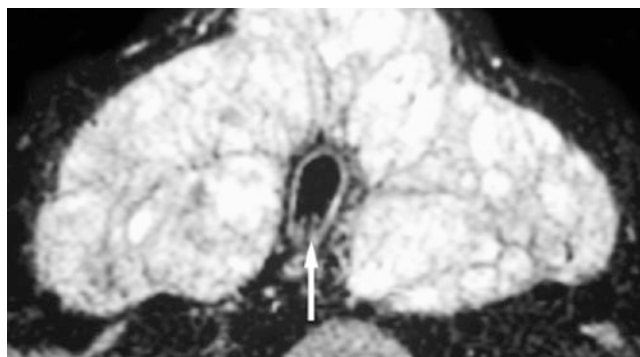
Goiter; 18-year-old presenting with hyperthyroidism. Axial T2-weighted fat-suppressed MRI shows large multilobulated thyroid gland compressing and narrowing trachea (*arrow*)
